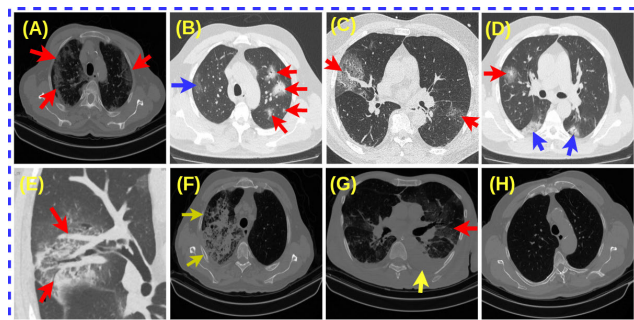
The clinical imaging observations of COVID-19 and CAP in chest CT scans. Images (A)-(E) show the COVID-19 patient's chest CT scan slices, (F) and (G) show the CAP patient's chest CT scan slices. (A) Peripheral distribution of GGO in both lungs (red arrows). (B) Patchy areas of consolidations in the left lung (red arrow) and GGOs in the right lung (blue arrow). (C) Crazy paving pattern: GGOs with superimposed septal thickening (red arrows), consolidations at the lower lobes of lungs (blue arrow). (D) Halo sign: consolidations surrounded by GGOs (red arrows). (E) Subsegmental vessel enlargement near the lesion (red arrows). (F) An extensive area of consolidations with GGO in the right lung – severe disease. (G) Pleural effusion (blue arrow) and GGOs (red arrows) in the left lung. (H) Normal chest CT scan slice.
